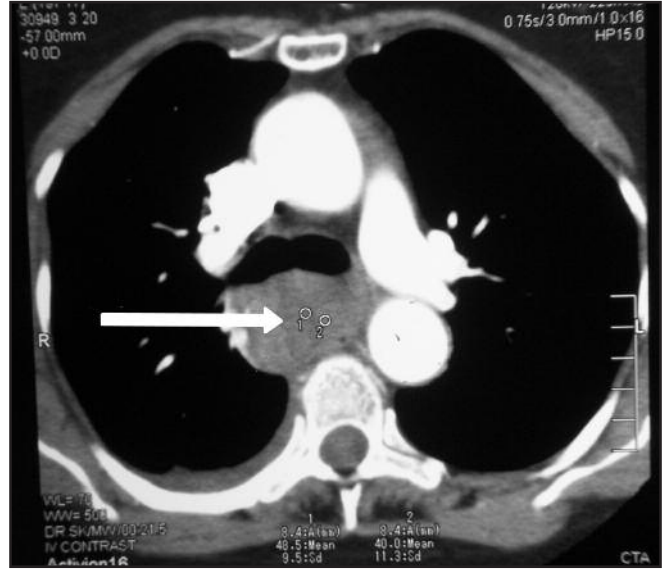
Contrast enhanced helical CT scan of the chest showing the eccentric, submucosal, hyperdense lesion suggestive of an oesophageal haematoma
